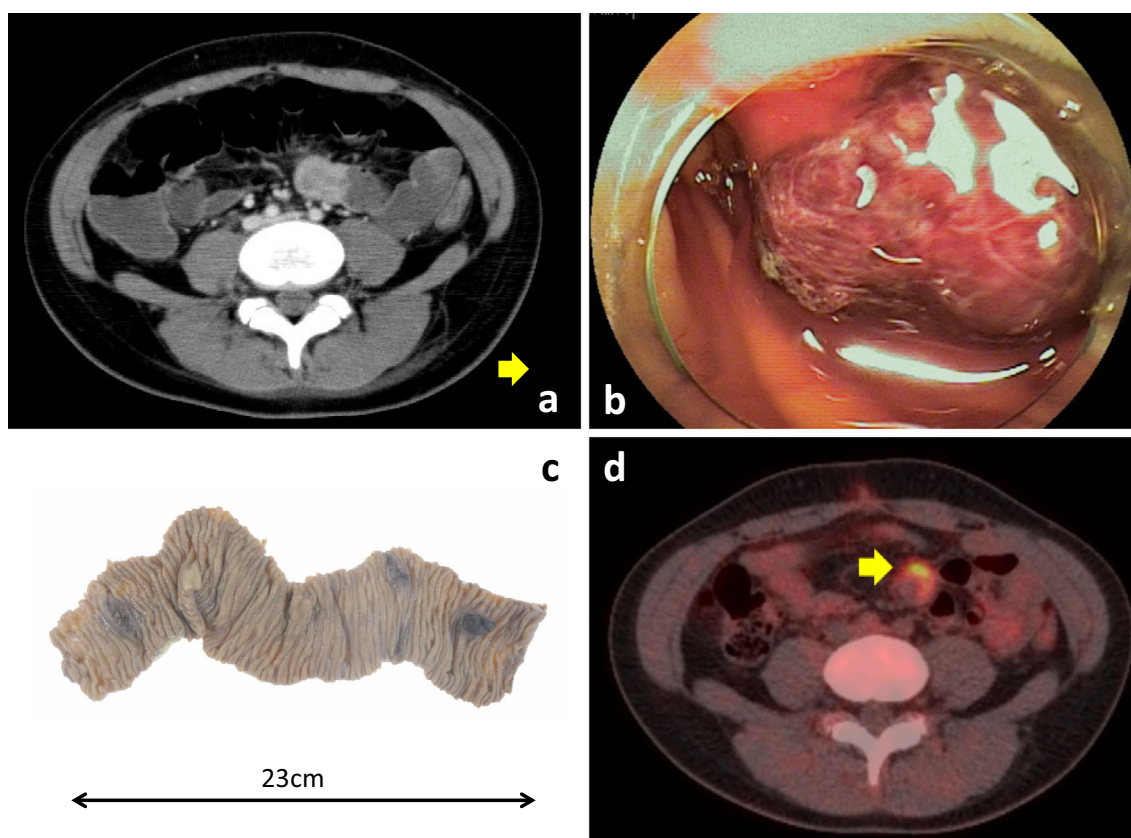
(a) Abdominal CT during an episode of melena showed a partially high density area in the small intestine. (b) The small-bowel endoscopic findings showed a tumor with distended vessels and bleeding. (c) The partially resected small intestine showed multiple blackish lesions with ulcer formation. (d) Delayed imaging PET/CT (obtained postoperatively) shows the uptake of FDG in the small intestine. FDG: ^{18}F -fluorodeoxyglucose
